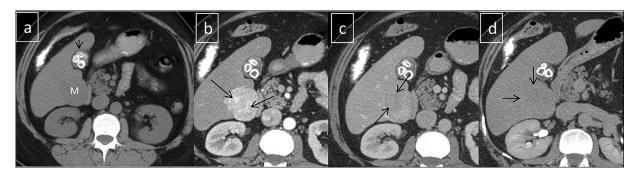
First computed tomography examination during the initial presentation (patient age 47 years): the primary lesion in the right hepatic lobe which is slightly hypoattenuating to the remainder of the liver parenchyma (M) on the nonenhanced computed tomography (a). It demonstrates heterogeneous avid enhancement on the arterial phase (b). Note the linear intralesional structures which represent prominent vessels centrally in the lesion and at the periphery (arrows in b). On the portal venous phase, the mass demonstrates mild washout, best seen in the right lateral part (arrows in c). Pseudocapsule is seen on the delayed phase (arrows in d) while the mass demonstrates mild washout (d). Incidental note is made of multiple hyperdense gallbladder stones (short arrow in a).
